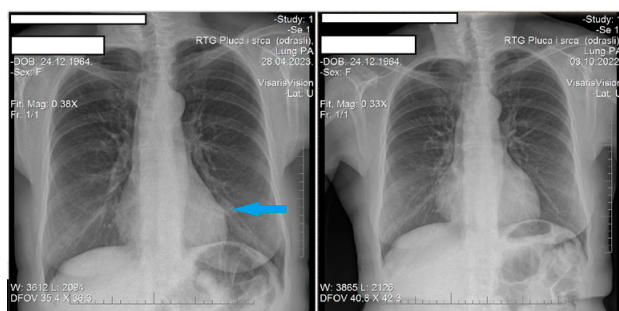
Chest X-rays – postero-anterior (PA), April 2023 and October 2022
